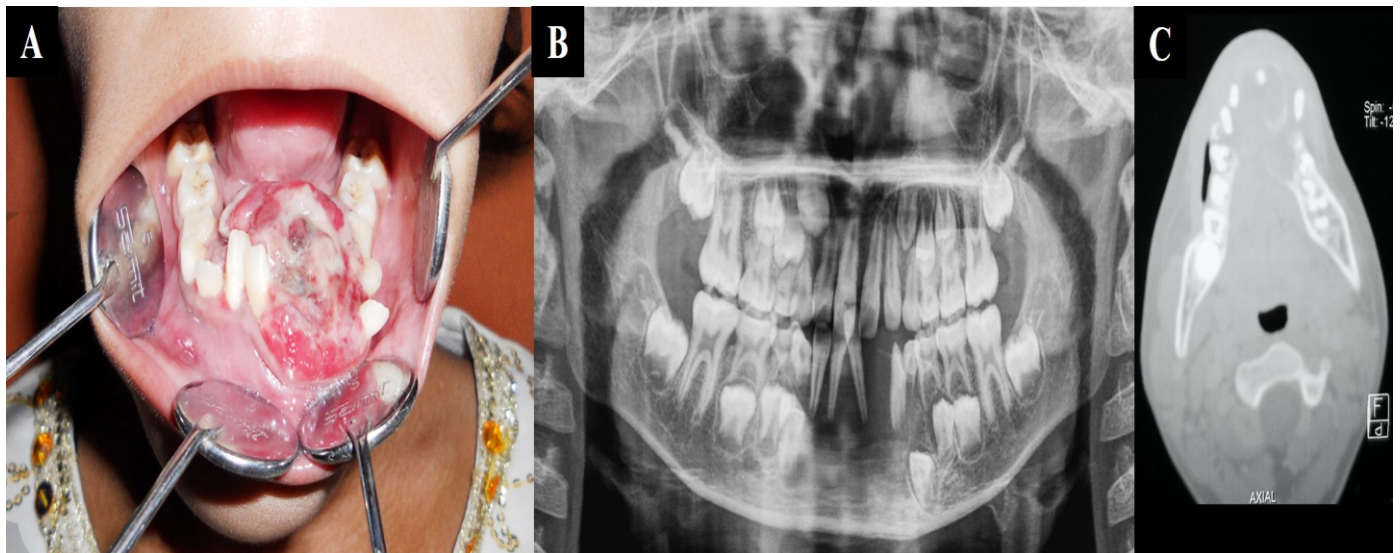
Clinico-radiographical features of primary tumour (A) Intraoral view showing ulceroproliferative of the mandibular anterior region before incisional biopsy; (B) Orthopantomogram showing large radiolucent area in the symphyseal region, displacing the incisors; (C) Axial CT scan showing heterogeneously enhancing lesion in the mandibular anterior region with labial and lingual cortical perforation.
